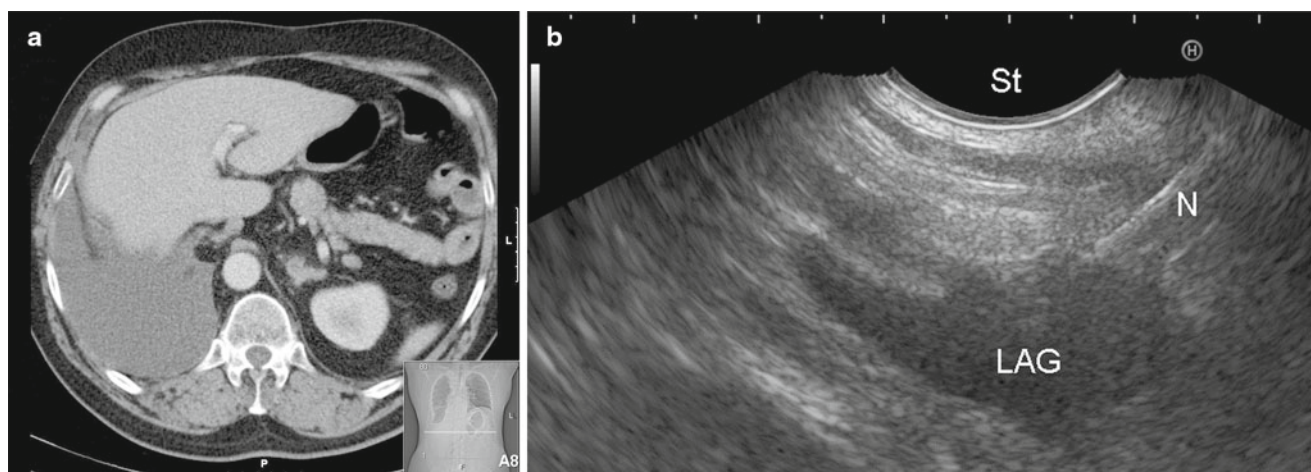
(a) CT image of a slightly enlarged, hypodense left adrenal gland in a patient with NSCLC. (b) Corresponding EUS images, demonstrating a transgastric needle (*N* needle) aspirate of the left adrenal gland. The typical “seagull shape” is absent (Refs. [1–53])
